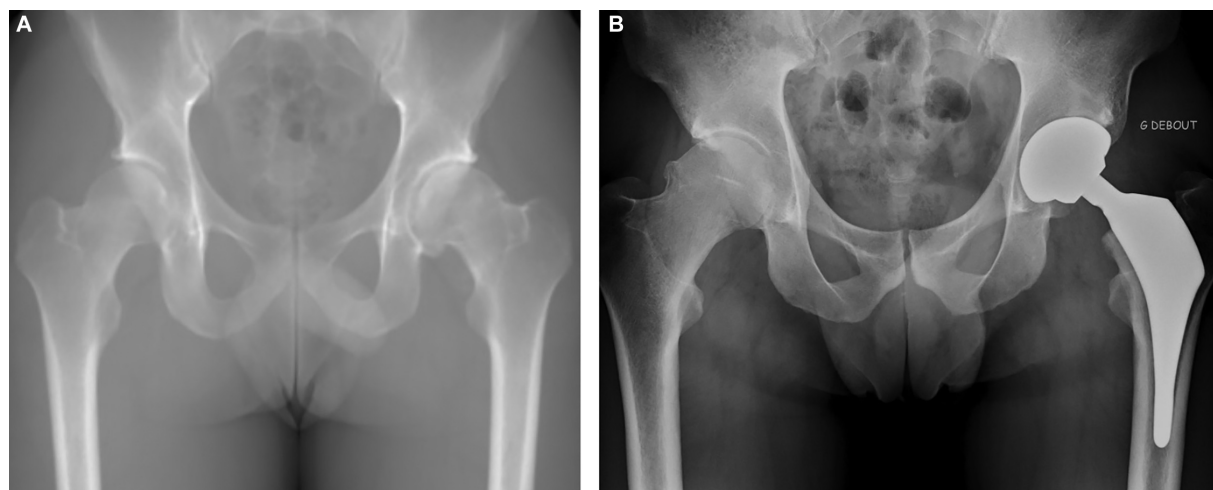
Preoperative (A) and postoperative (B) pelvic radiographs of a professional male table tennis player, aged 26 years.
